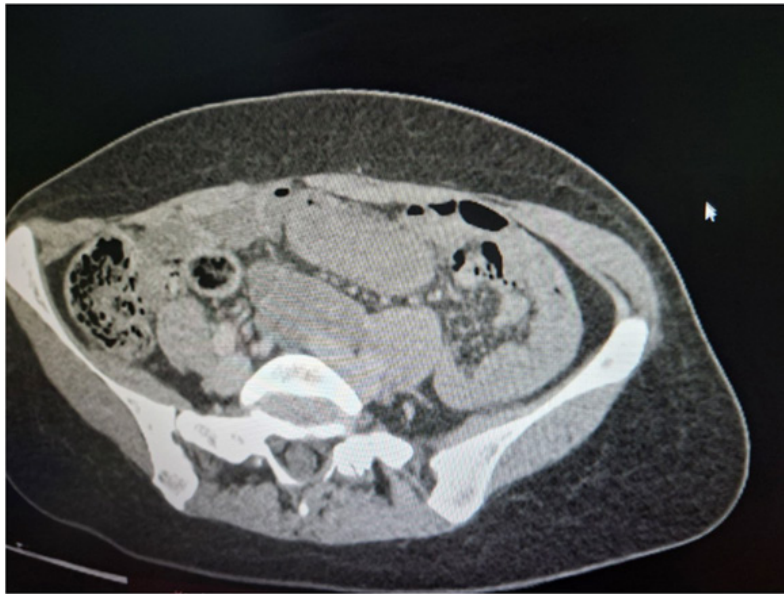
Contrast-enhanced CT image demonstrating dilated small bowel loops without definitive transition point or overt signs of ischemia.
